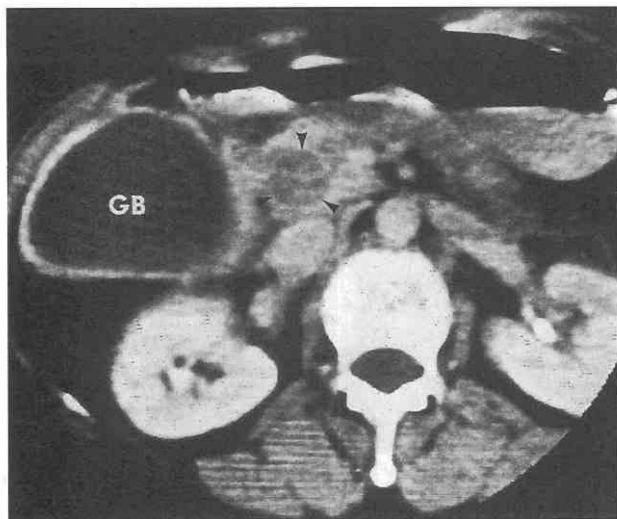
Arrowheads show dilated common duct in the pancreatic head, filled with a calculus of higher attenuation than bile in the gallbladder (GB). (From Choi BI, Kim HJ, Han MC: CT findings of clonorchiasis. *Am J Roentgenol* 152:281, 1989.)
